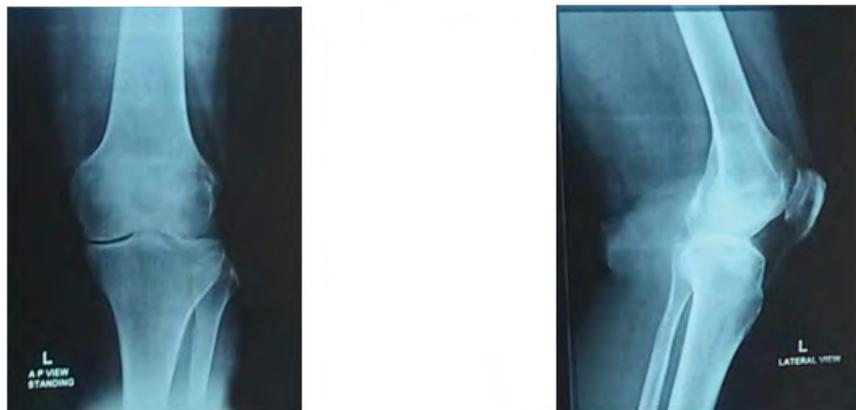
(a and b) X-ray pictures showing clear joint space narrowing during pre-treatment by the test product.
